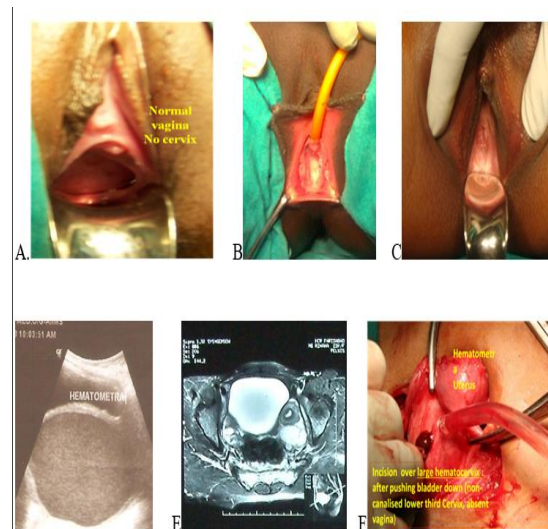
A. Showing a normal vagina but no cervix. B- Blind vagina in complete vaginal aplasia. C-Blind vagina in partial upper vaginal aplasia. D-Ultrasound showing large hematometra. E-MRI showing large hematometra. F- Hematometra, and hematocervix at laparotomy.
